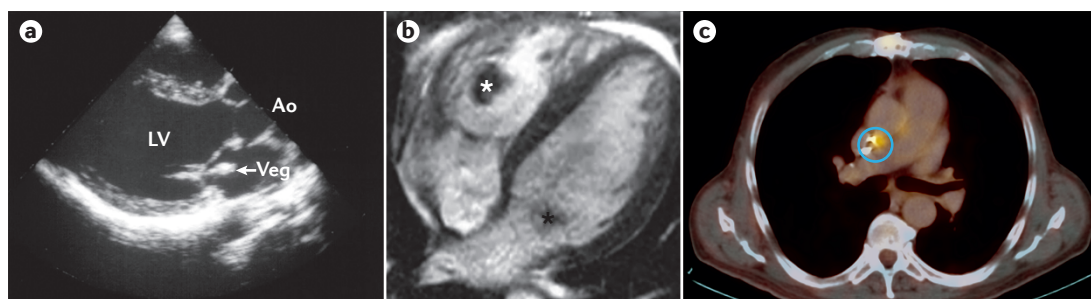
Imaging modalities for the diagnosis of IE. a | Transthoracic echocardiography demonstrating native mitral valve vegetation. b | Cardiac MRI (systolic frame) demonstrating vegetations in the sub-tricuspid valve chordal apparatus with an adherent thrombus (white asterisk) and a posterior mitral valve leaflet (black asterisk). c | In this patient, infection of a prosthetic aortic valve was suspected but echocardiography was inconclusive. Using PET-CT, inflammatory leukocytes are visualized after taking up radiolabeled glucose, showing an area of active infection on the aortic valve (blue circle). Ao, aorta; IE, infective endocarditis; LV, left ventricle; Veg, vegetation. Image in part b courtesy of A. L. Crowley, Duke University School of Medicine, Durham, North Carolina, USA, and image in part c courtesy of N. E. Bruun, Gentofte Hospital, Copenhagen, Denmark.
